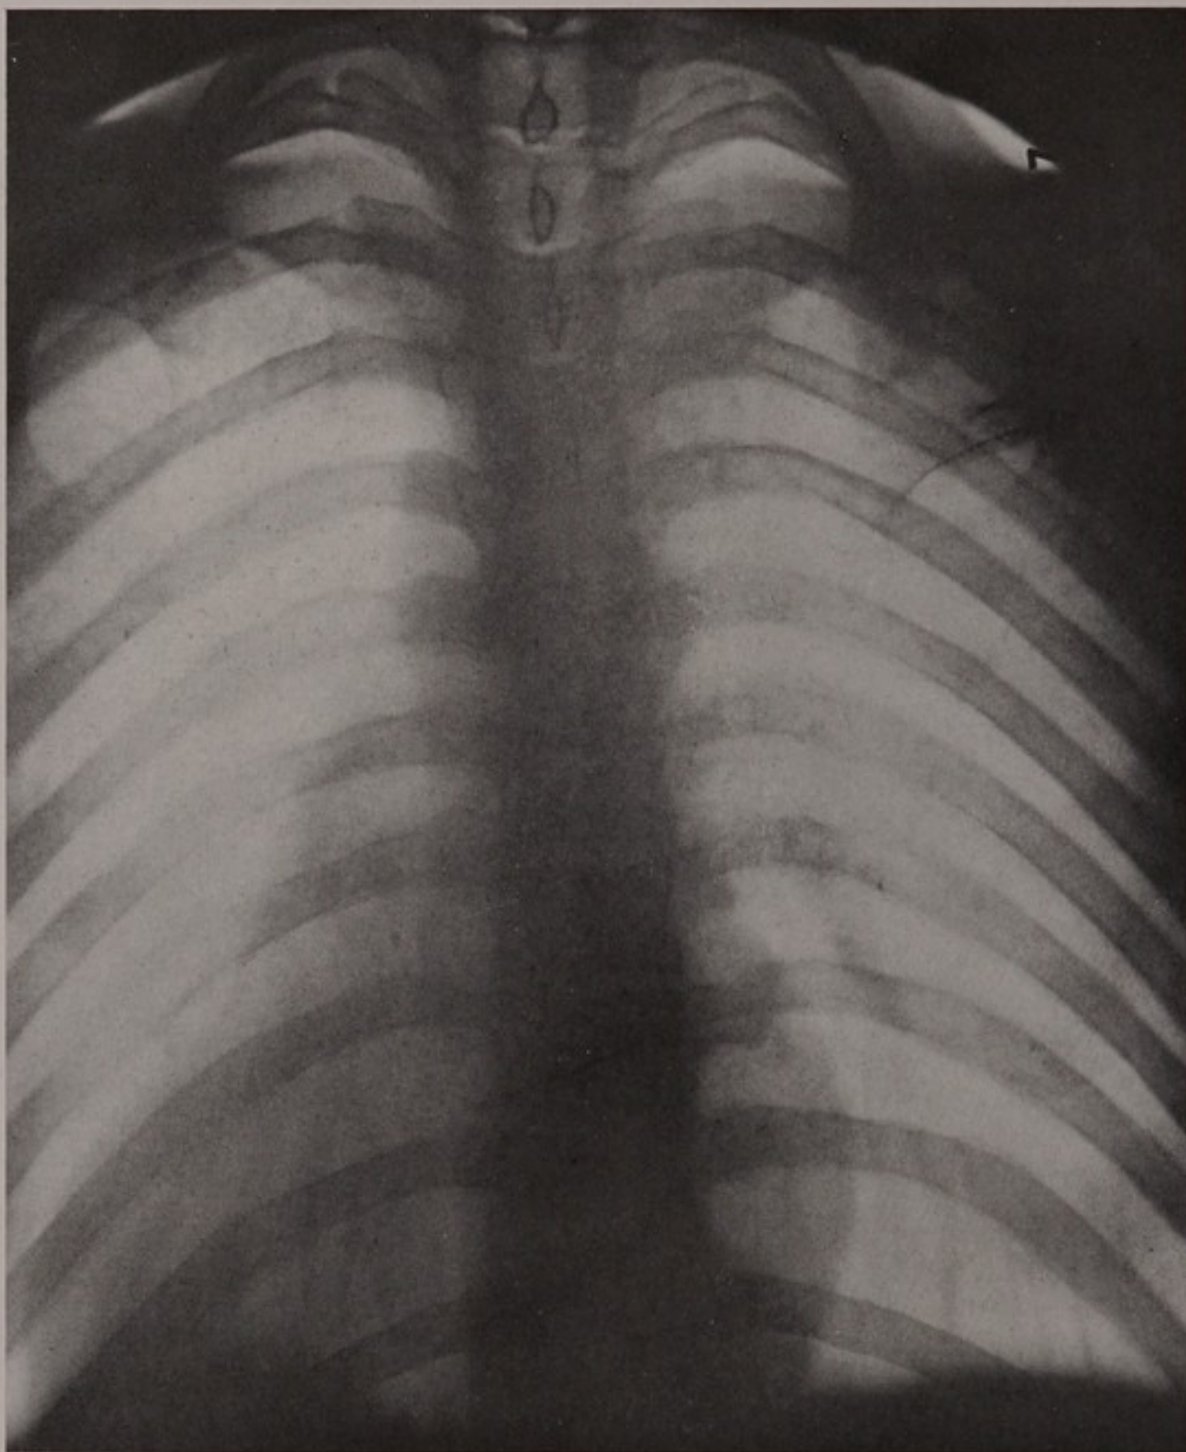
X-ray of the dorsal vertebræ from in front.
